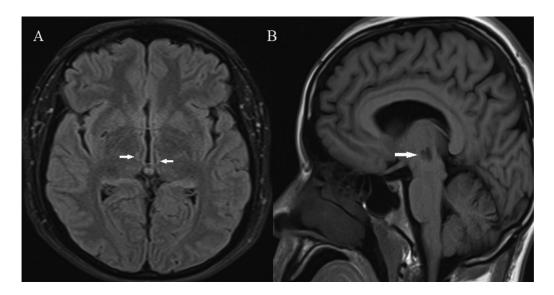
MRI control on axial FLAIR sequence (A) showed lacunar infarct of bilateral paramedian thalami (arrows). Sagittal T1 sequence (B) found low signal intensity in the rostral mesencephalon (arrow).
